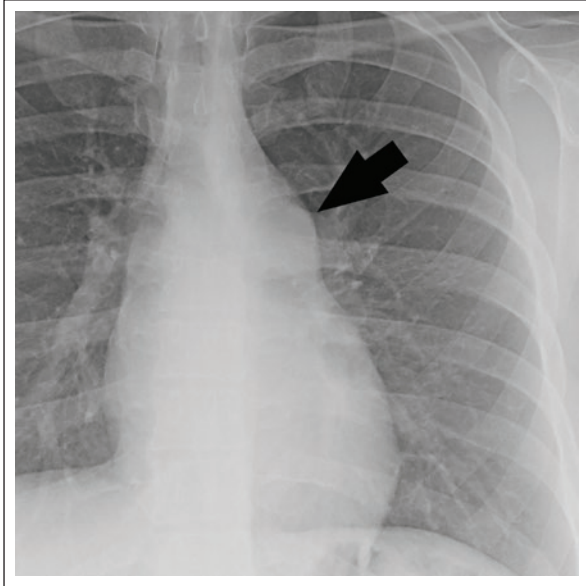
Patient with pulmonary hypertension showing the hilum convergence sign. Chest radiograph shows abnormal left hilar convexity (arrow). Note that the hilar vessels reach the edge but are not seen through the hilar convexity.
